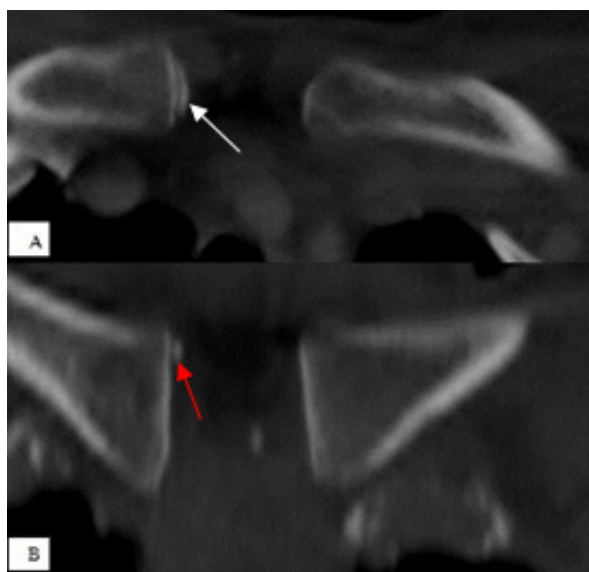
(A, B) CT images of medial clavicles of a 31 year old female show the accessory ossicle imitating the epiphyseal ossification center on the right side on axial (A, white arrow) and coronal (B, red arrow) images
